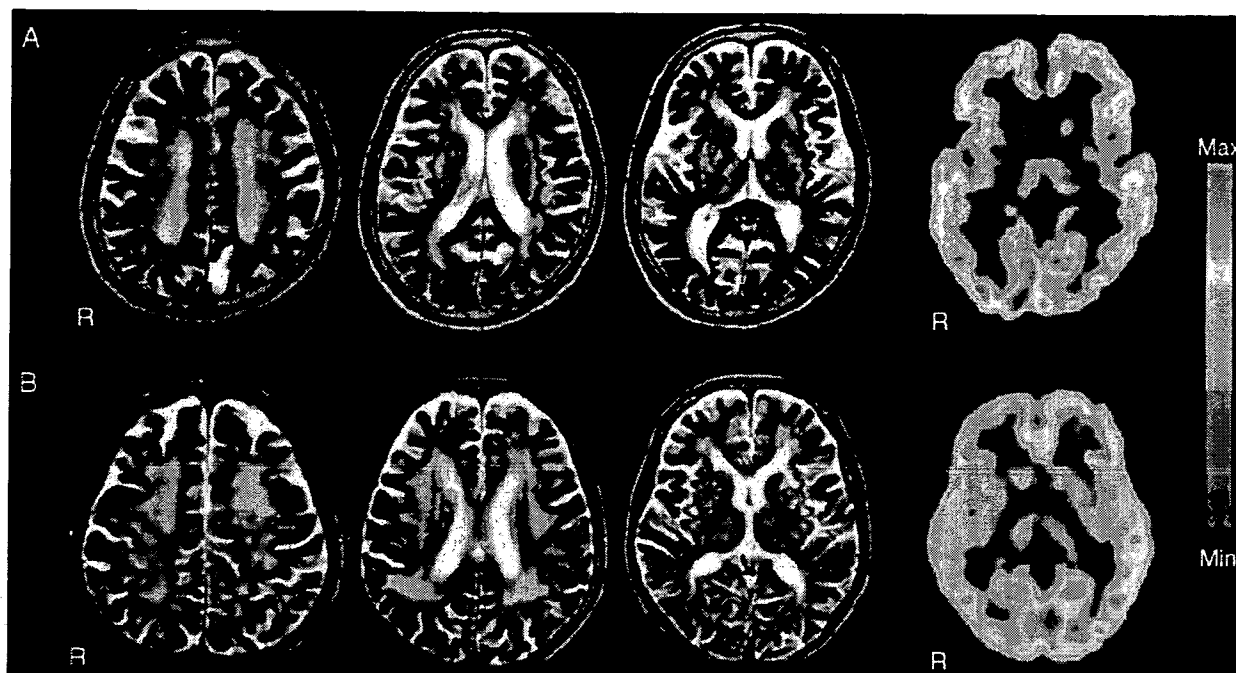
Representative T2-weighted MRIs and parametric PET images of FMZ- V_d in two patients with WMLs (A, gait disturbance; B, no gait disturbance). FMZ- V_d values are noted in the pseudocolor scale ranging from 0 to 10 ml/gm. *R* indicates right
